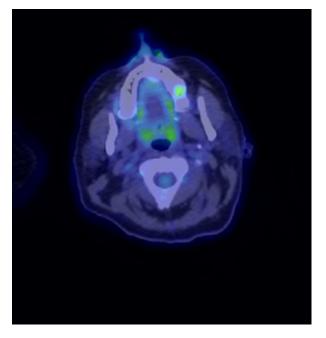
Positive emission tomography fused with computerised tomography to demonstrate moderate FDG uptake in left posterior maxilla in 4 years prior to presentation. Date of exposure: 19 September 2013.
